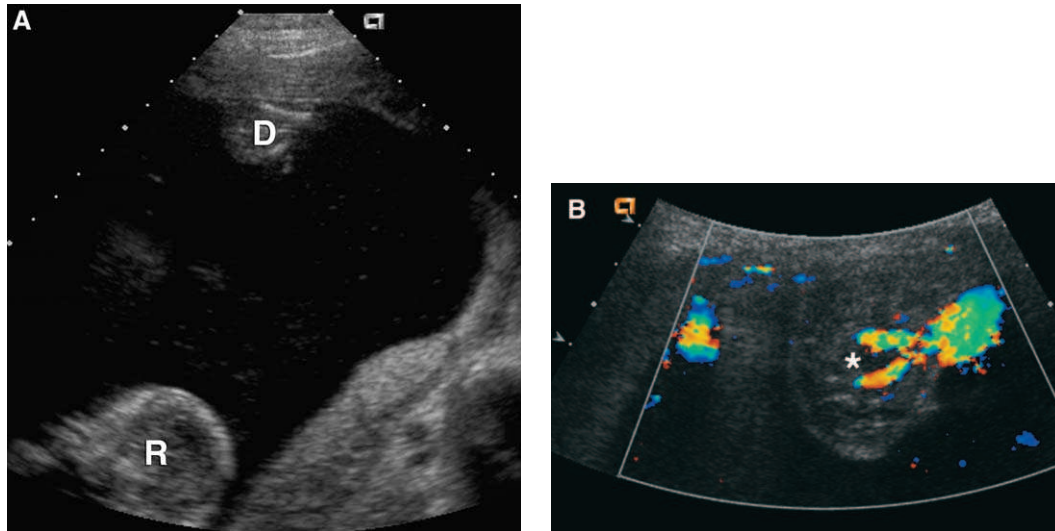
(A) Severe twin-twin transfusion syndrome. There is marked polyhydramnios of the recipient twin (R) and marked oligohydramnios of the donor twin (D), which appears “stuck” adjacent to the anterior uterine wall. (B) Color Doppler sonogram through the pelvis of the stuck twin shows flow in the umbilical arteries, flanking an empty urinary bladder (\*).
